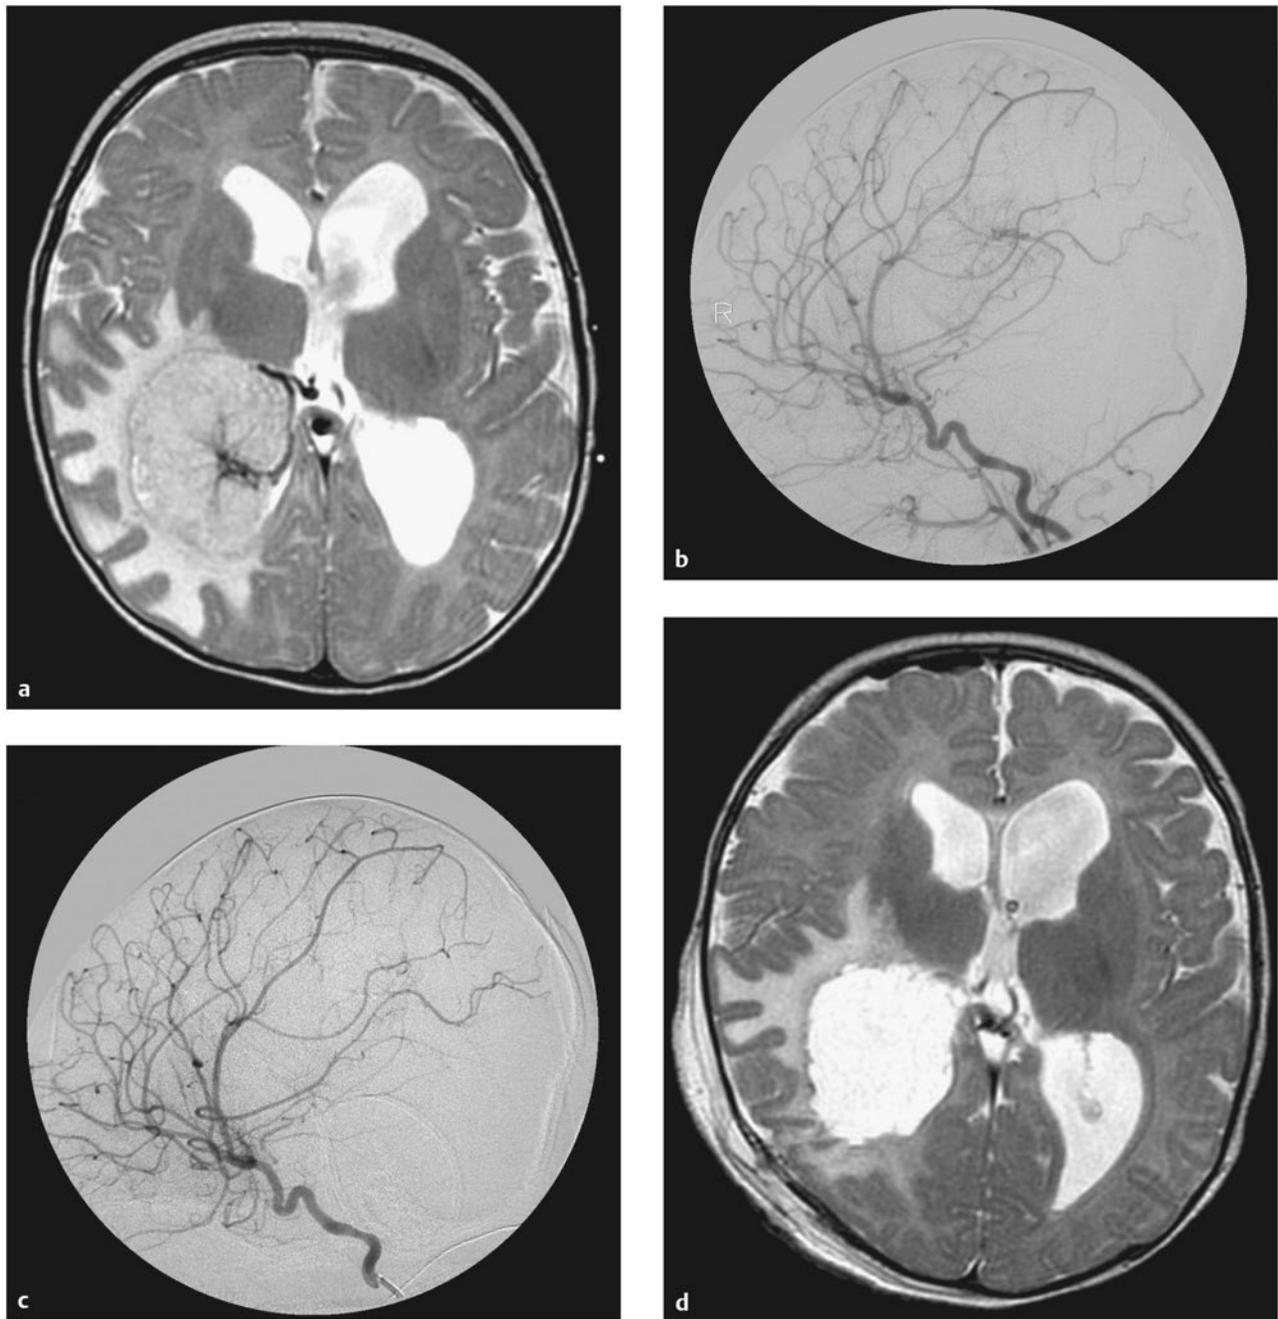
Choroid plexus papilloma. Representative magnetic resonance images from a 4-month-old boy who was evaluated for increasing head circumference. (a) An axial T2-weighted image revealed a large left intraventricular mass and ventriculomegaly. Given the expected tumor vascularity, (b) an angiogram was obtained that confirmed the presence of a very rich arterial supply. The lateral projection of the right internal carotid artery depicts the tumor blush principally from the right anterior choroidal artery. (c) The postembolization angiogram demonstrates a reduction in vascular blush. (d) The postoperative axial T2-weighted image confirms that a gross total excision of the tumor was accomplished.
